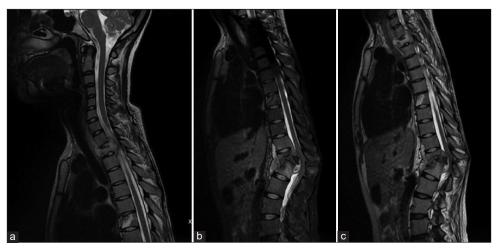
MRI of spinal TB in 20-year-old female. (a) Contrast MRI showed lesion at corpus vertebrae at T2 level; (b-c) compression fracture of the corpus vertebrae at T11 and T12 level.
